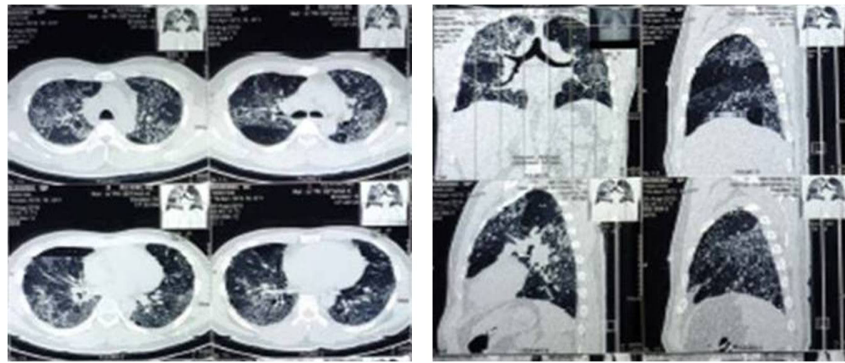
A Thorax CT scan showed interstitial pneumonia results in a differential diagnosis of interstitial lung disease with heart size within normal limits.
